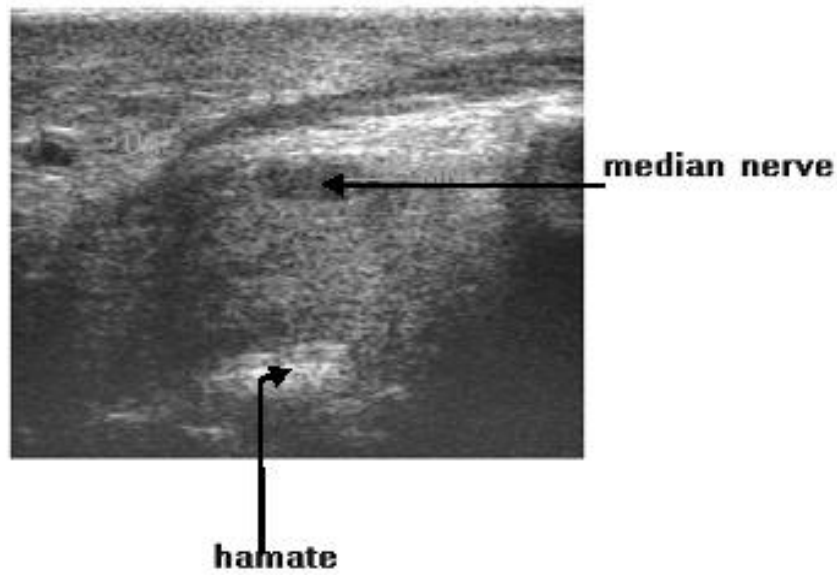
Ultrasonographic image distal to the carpal tunnel
